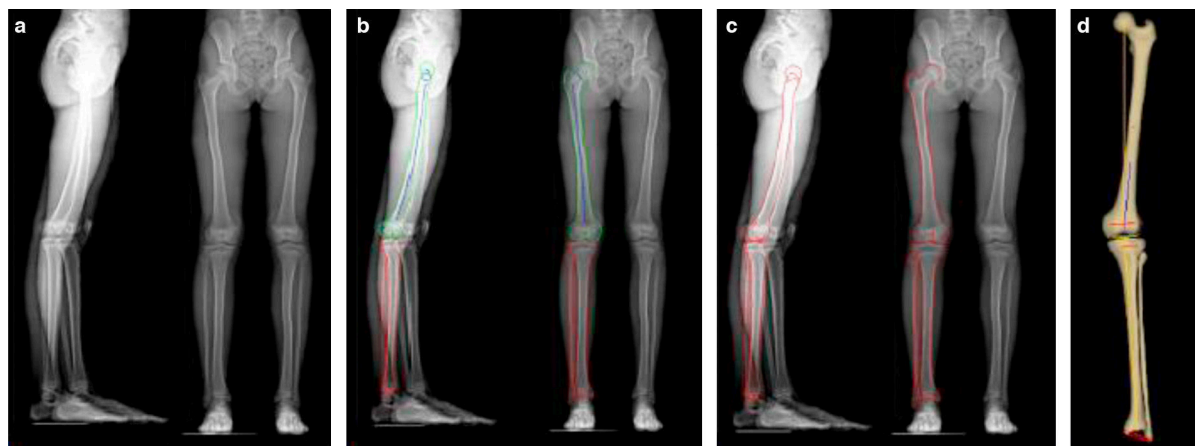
Different steps of the reconstruction method: a) biplanar X-ray before 3D reconstruction; b) the operator was asked to adjust 3 circles representing the projection of the femoral head and the femoral condyles on both X-ray radiographs. Those projections were optimized by semiautomatic identification of a few anatomical landmarks, permitting computation of an initial model that was superimposed on the X-ray; c) further adjustments were made, so as to adjust the contours to the anatomical landmarks; d) 3D lower limb obtained were automatically calculated.
